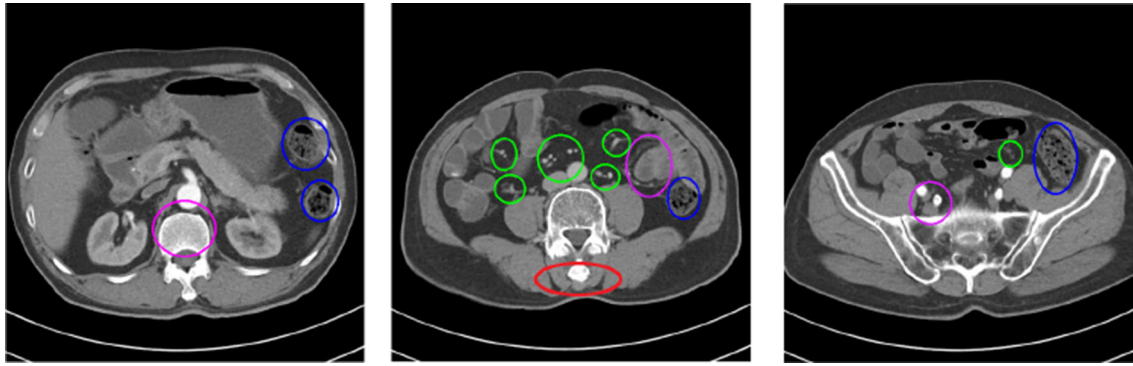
Representative issues on CT images.
